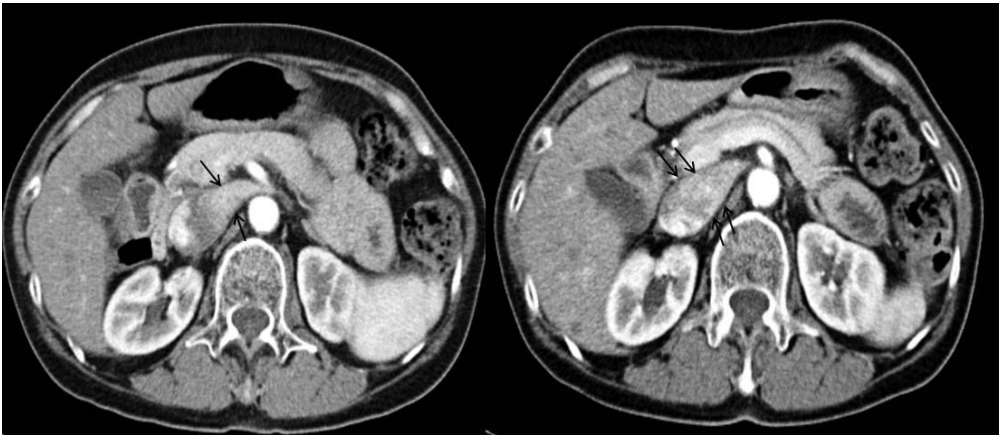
Nutcracker syndrome. Contrast-enhanced CT image of a 66-year-old female in the early arterial phase. Preferential flow of contrast medium is observed along the anterior non-dependent margin of the left renal vein and inferior vena cava due to high flow velocity, suggestive of nutcracker syndrome (arrows).
